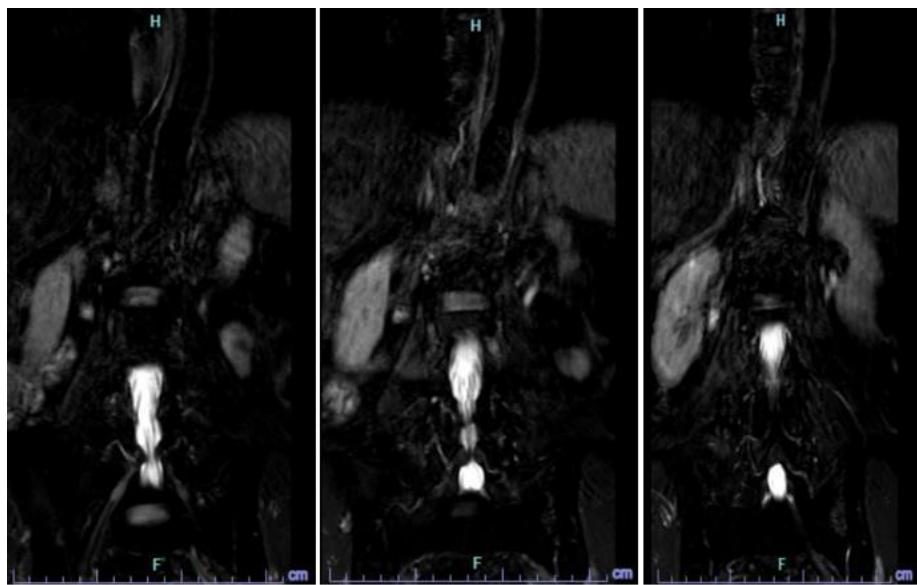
MRI Sequence (T2W_mdixon_cor) image shows the presence of secondary spinal canal stenosis in coronal view
